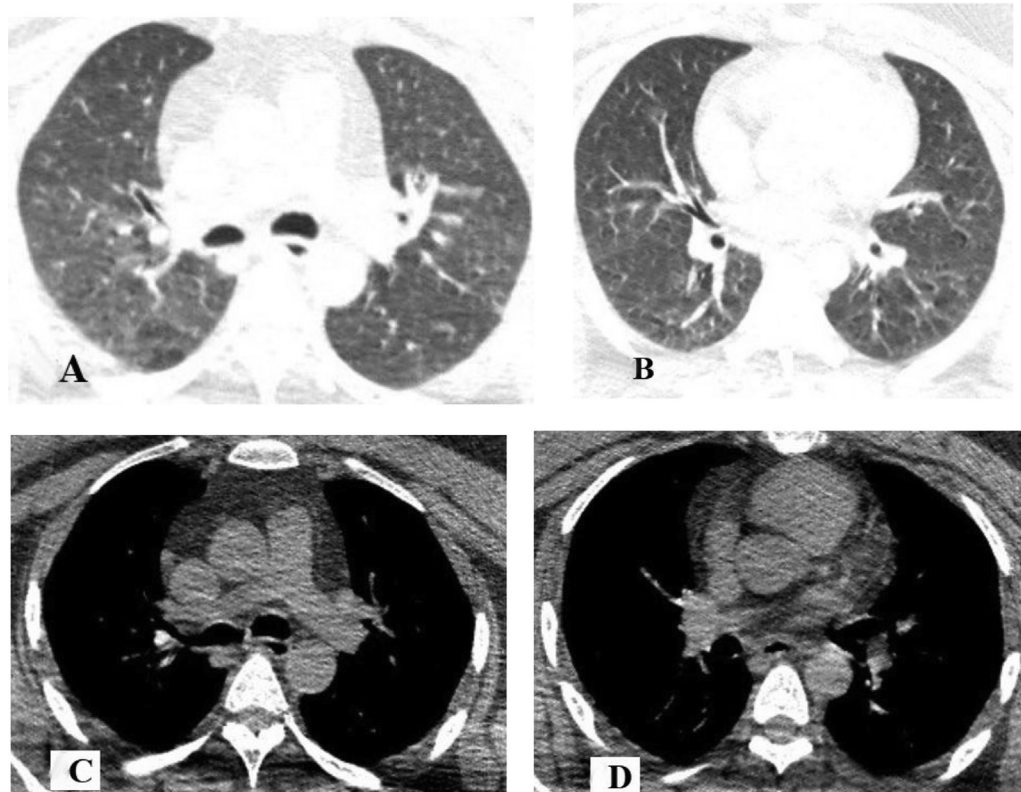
A high-resolution CT of the chest was performed to rule out tuberculous lesions in the chest and mediastinum. No obvious tuberculous lesions were seen in the lungs and mediastinum.
